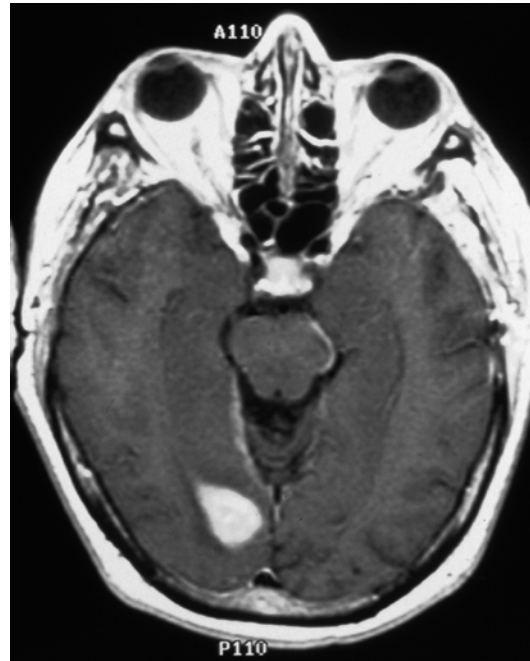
Contrast-enhanced T₁-weighted axial MRI of the brain showing extension of glioblastoma along the optic radiations to the visual cortex in the occipital pole (From Cummings [171], Figure 8.10, Page 162. With kind permission of Springer Science + Business Media)
